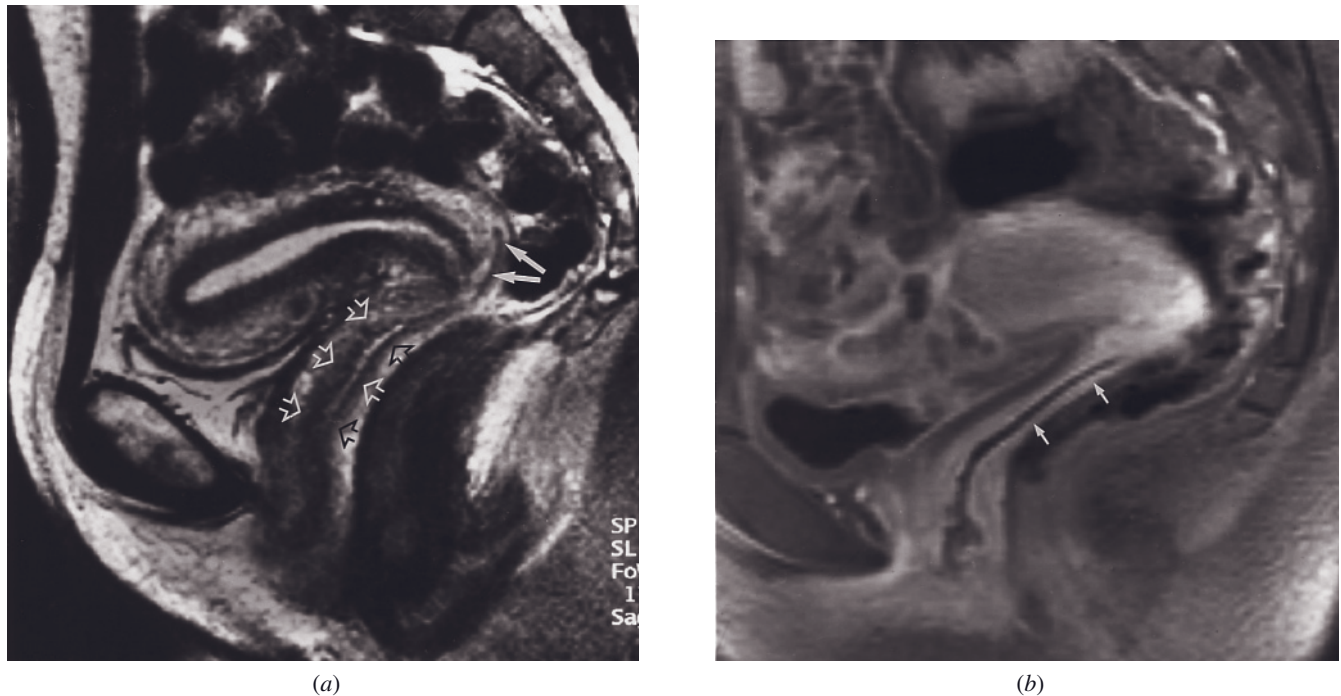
Normal vagina. Sagittal T2-weighted echo-train spin-echo (a) and immediate postgadolinium fat-suppressed SGE (b) images. On the T2-weighted images, the low-signal-intensity muscular wall and the central higher-signal-intensity mucosal layer of the vagina are apparent. The sagittal T2-weighted image (a) shows vagina (open arrows) as well as the posterior vaginal fornix (solid arrows). Relationship with uterus and cervix is well seen. On the immediate postgadolinium fat-suppressed image (b), intense enhancement of vaginal mucosa (arrows) is present. (Courtesy of Susan M. Asher, M.D., Dept. of Radiology, Georgetown University Medical Center, Washington, DC.)
